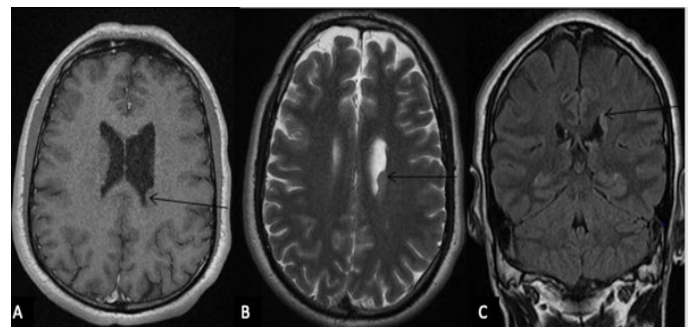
16-year-old girl, partial phramco-resitant epilepsy with MRI on T1 2A) T2 2B) and FLAIR 2C) sequences, periventricular nodular form of gray matter heterotopia.
